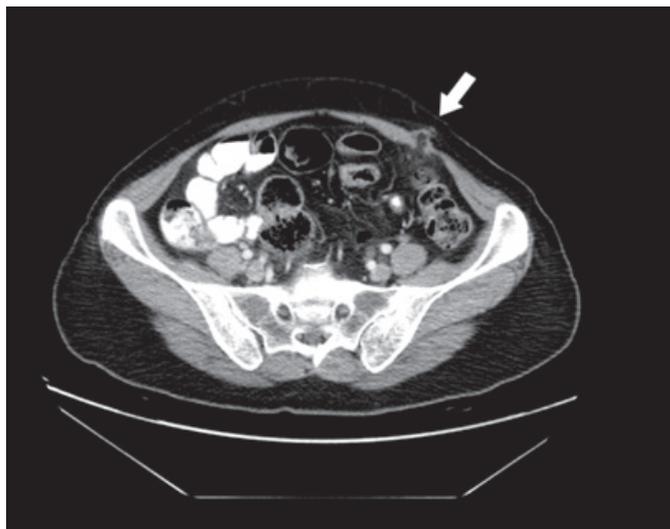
Trocar site hernia, located in the left lower quadrant was shown in axial computed tomography image.
